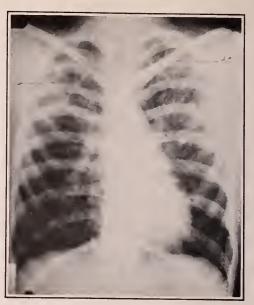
Case II. Roentgenogram of December, 1930, showing cavity at each apex (a and b), and exudative involvment through both upper lung fields.
